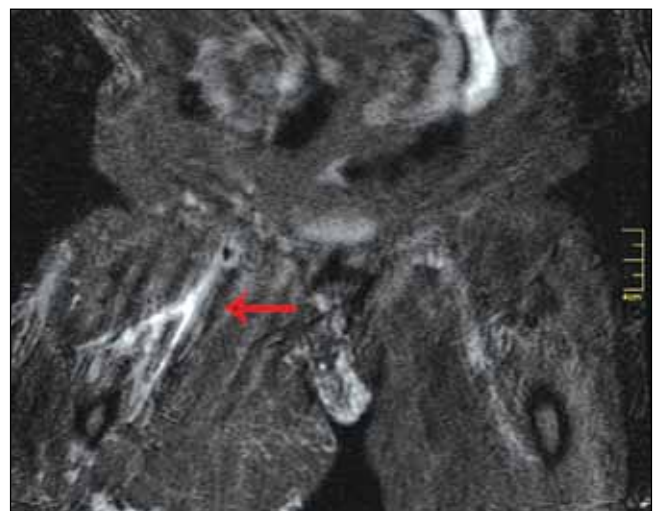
Expansion of deep venous structures in limb MRI.
